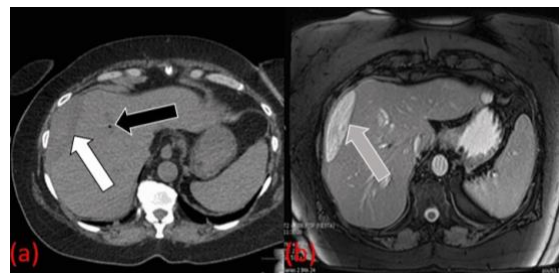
(a) CT scan showing Abscess drainage catheter remains in the gallbladder fossa region. Fluid collection has decreased in size (black arrow). There is a relatively isodense and hypodense subcapsular hematoma in the lateral right lobe of the liver with maximum thickness of 2.8 cm. It is approximately 8.5 cm anteroposterior and 10 cm craniocaudal (white arrow). (b) MRI shows subcapsular hematoma on the right lobe of liver (grey arrow).
